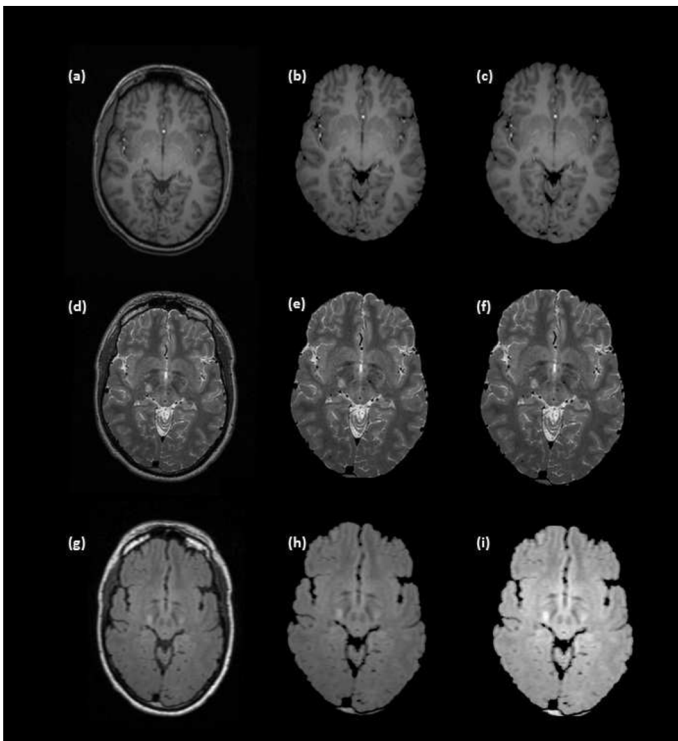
Preprocessing steps: (a) a given T1-w image slice, (b) skull-stripped T1-w image slice, (c) skull-stripped and unbiased T1-w image slice, (d) a given T2-w image slice, (e) skull-stripped T2-w image slice, (f) skull-stripped and unbiased T2-w image slice, (g) a give FLAIR image slice, (h) skull-stripped FLAIR image slice, (i) skull-stripped and unbiased FLAIR image slice.
